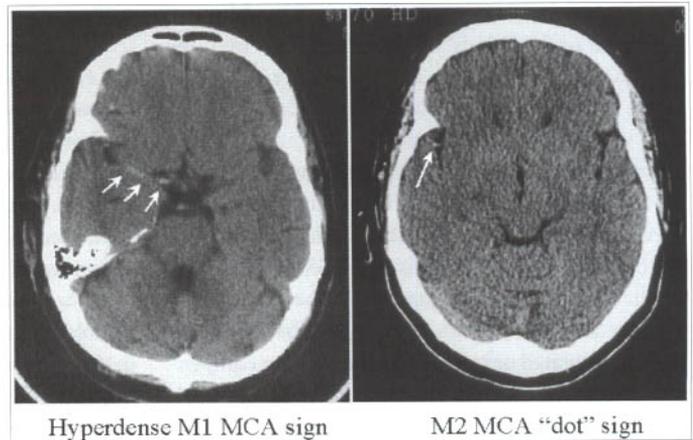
Hyperdense artery signs on a non-contrast CT scan. If present unilaterally, these signs indicate a thrombus in the M1 MCA segment (left image) or M2 subdivision (right image).
